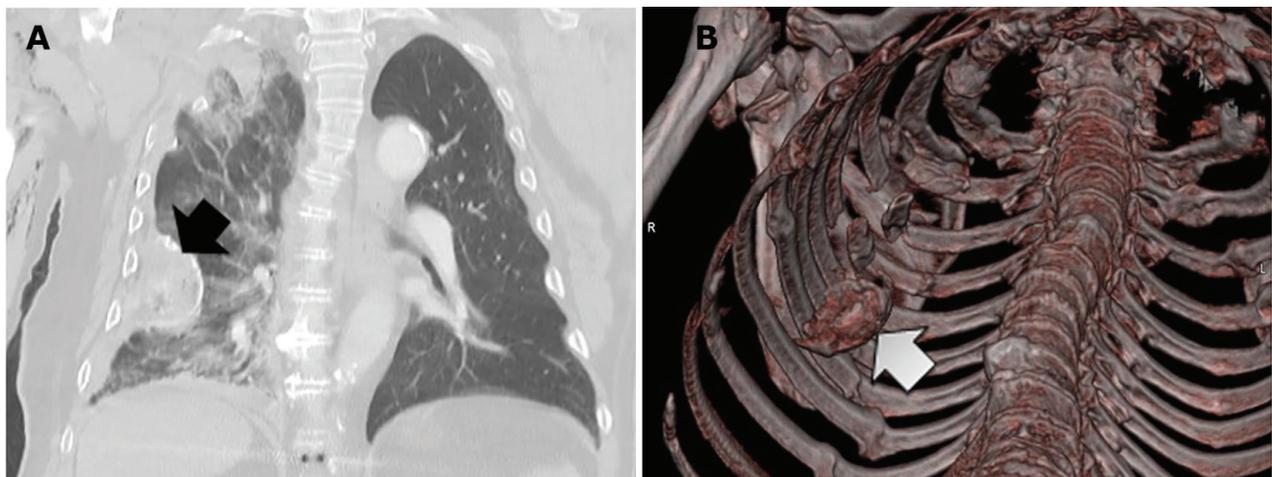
Coronal (A) and 3-dimensional reconstruction (B) CT-scan of the chest cavity demonstrating a hyperdense lesion in right hemithorax with a wide base in favour of the intrathoracic humeral head (arrow).
